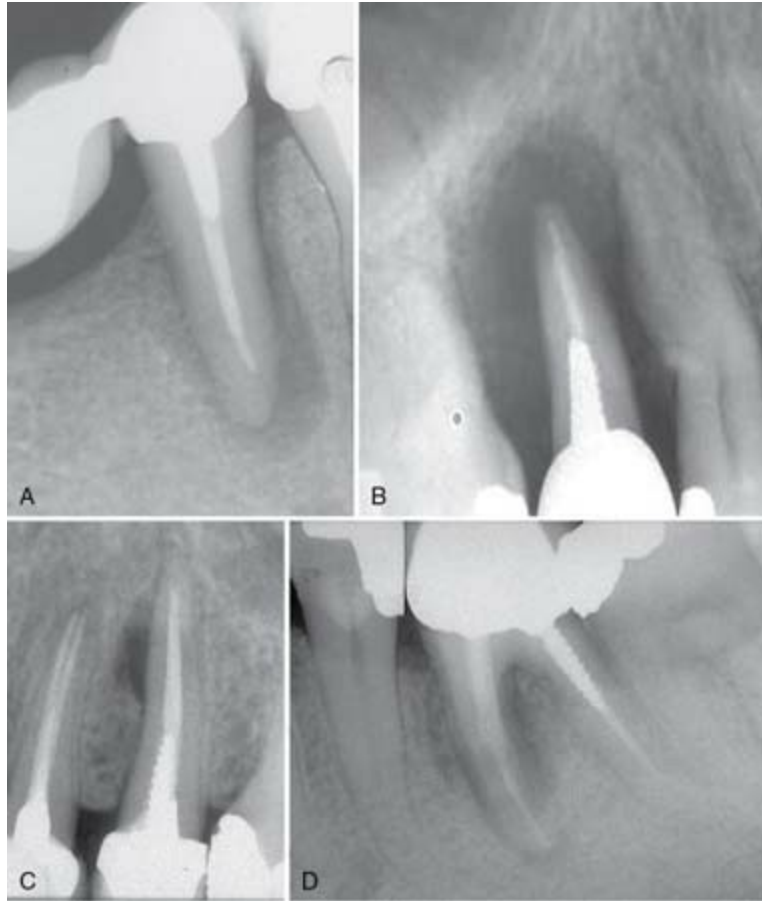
Radiographic presentations of longstanding vertical root fractures (VRFs). A, J-shaped “halo” associated with a VRF in a second right mandibular premolar. B, Extensive bone damage associated with a complete VRF in a second right maxillary premolar. C, Limited bone damage associated with a midroot VRF in a second left maxillary premolar. D, Bone damage associated with a VRF in the mesial root of a first left mandibular molar. All such presentations are typical of longstanding VRFs.
